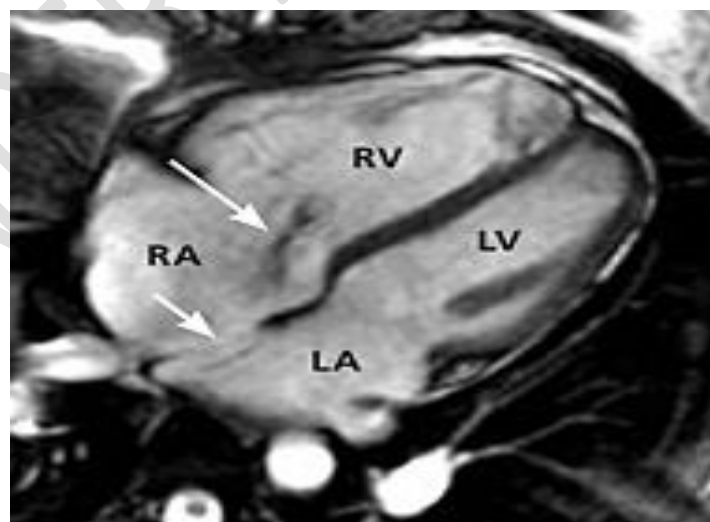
one of the atrial septal flaws (short arrow) is seen on magnetic resonance imaging, as well as enlargement of the right atrium and right ventricle. A systolic regurgitant flow jet (long arrow) can also be seen coming from the tricuspid valve in this image (19).
